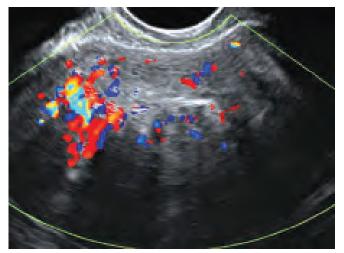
Feeding vessel of the endometrial polyp using color Doppler scan
